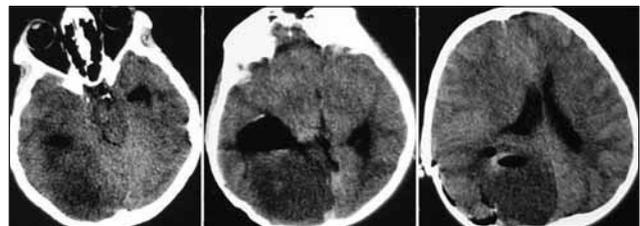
Cystic masses are not seen on early postoperative control CT scan.
